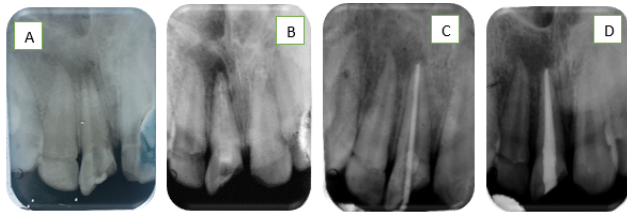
A: Pretreatment periapical view; B: Application of calcium hydroxide; C: Obturation carried out after 2 months D: Post treatment radiograph after 6 months
